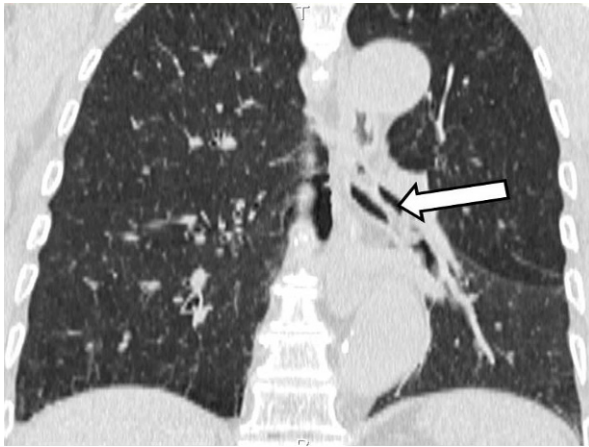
Coronal CT also revealed a large and long mass-like opacity in trachea and left main bronchus.
